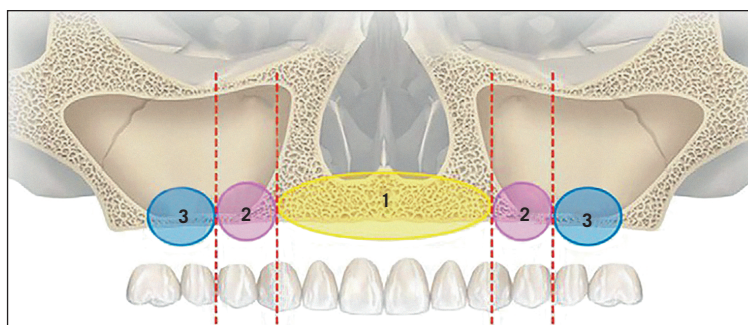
Radiographic zones used to determine extent of maxillary atrophy. (Reprinted with permission from Bedrossian E. Rescue implant concept: The expanded use of the zygoma implant in the graftless solutions. Oral Maxillofacial Surg Clin North Am 2011;23:257–276.)
